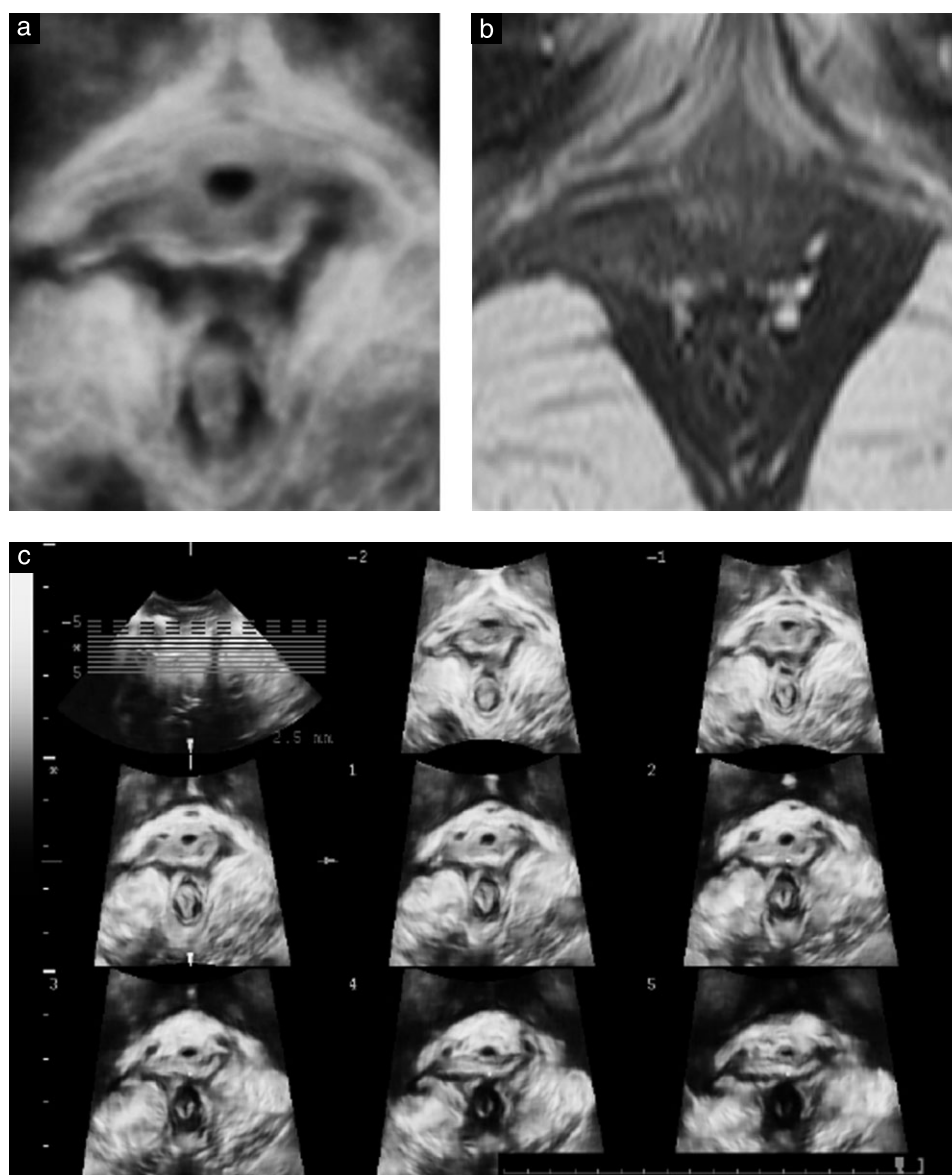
Typical right-sided levator avulsion injury as diagnosed 3 months after a normal vaginal delivery at term, on 3D ultrasound (a), magnetic resonance imaging (b) and tomographic ultrasound imaging (c). This patient was asymptomatic apart from deep dyspareunia.
